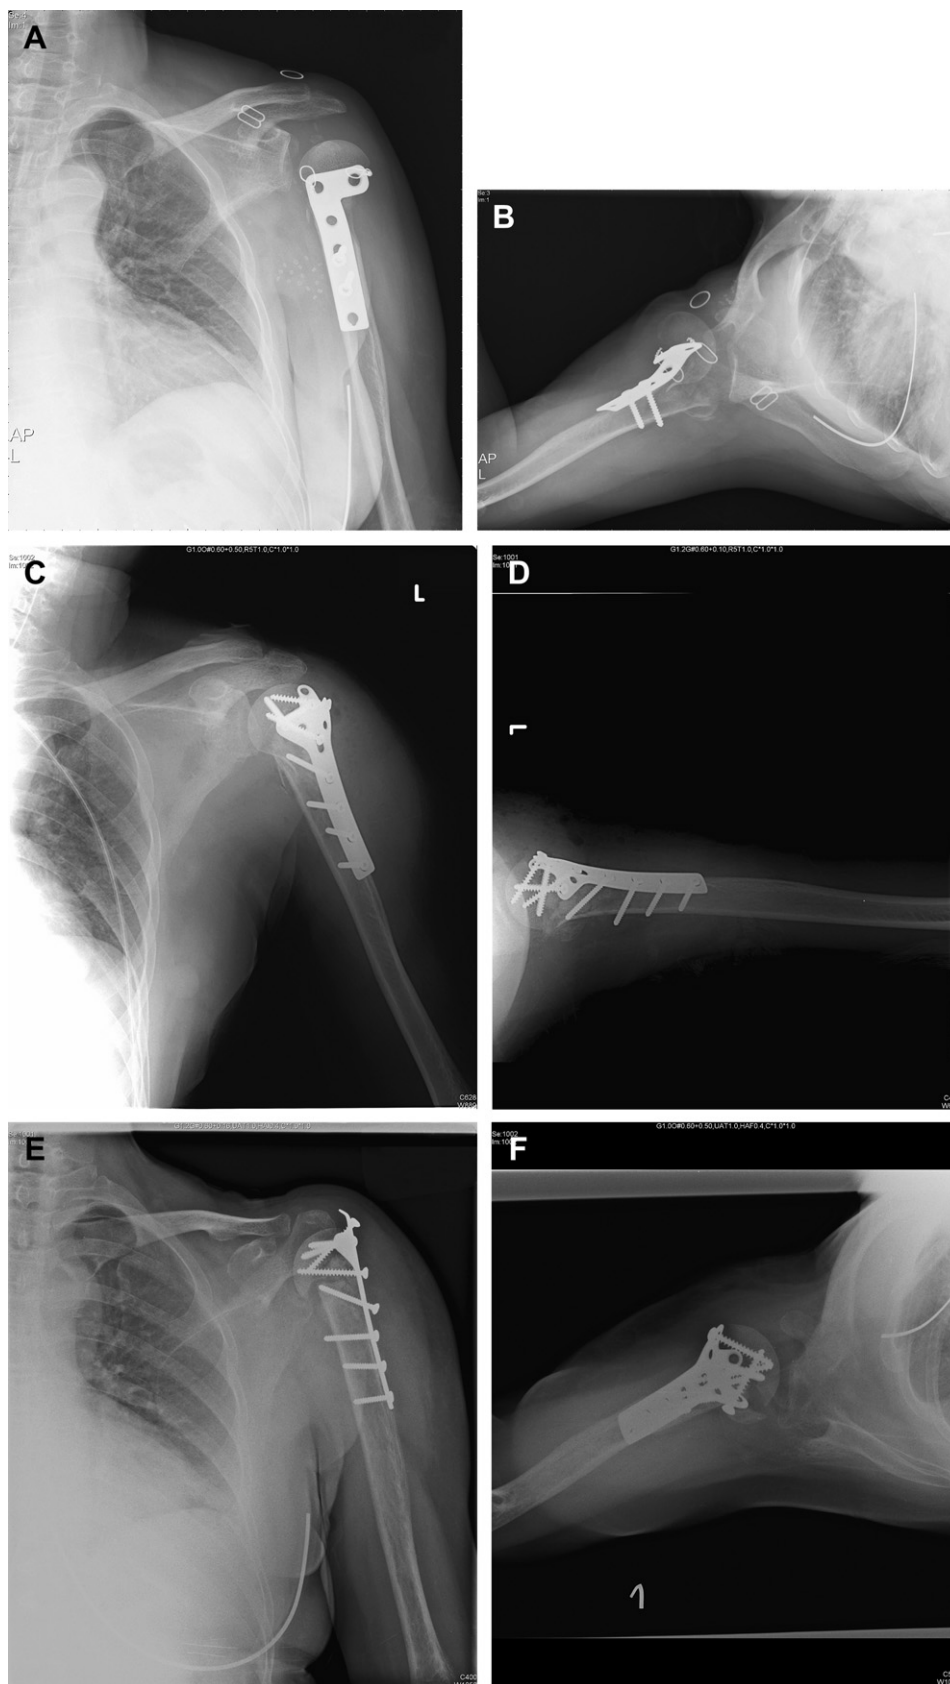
A 45-year-old woman had persistent anterior dislocation of the humeral head after the first surgery (A and B). After revision surgery, the proximal humerus seemed well reduced and fixed (C and D). However, radiography performed after 6 months revealed nonunion of the fracture site with resorption of the allograft (E and F).
